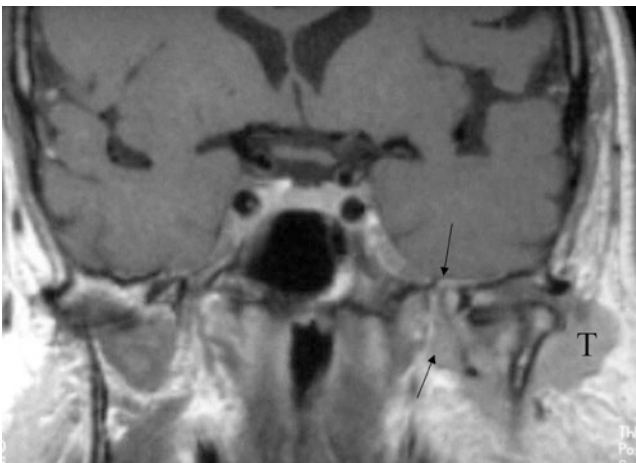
A patient with over a year of chronic, progressive facial pain with a working diagnosis of trigeminal neuralgia. The patient also eventually developed facial weakness. Recent prior outside imaging with both CT and MRI interpreted as negative. The otherwise occult (non-palpable) primary cancer in the left parotid gland (T) spread along the auriculotemporal nerve within the masticator space to access the mandibular division of the trigeminal nerve to spread as far proximally as the foramen ovale/trigeminal ganglion (arrows)
